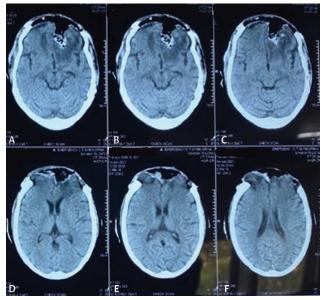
(A—F) Postoperative CT brain showing post op changes with complete excision of left frontal lesion.
